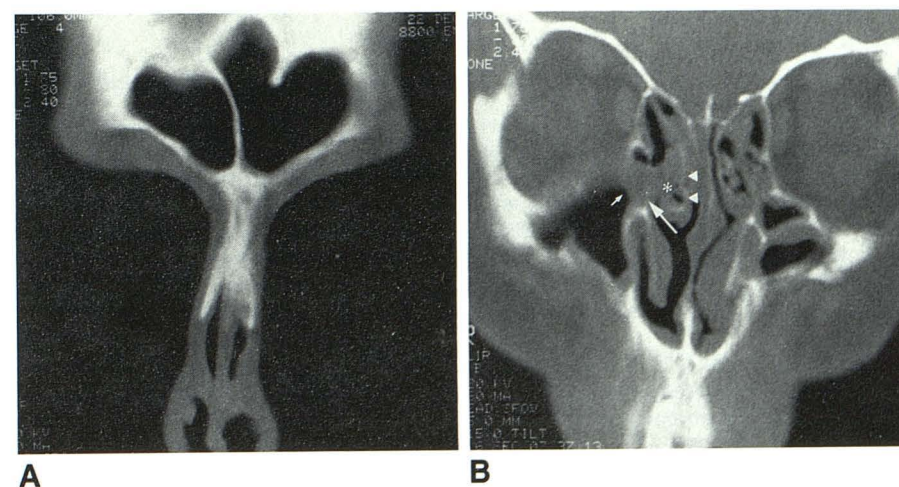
A and B, Normal frontal sinuses (A) and coronal CT scan at level of maxillary sinus ostia (B). Bilateral osteomeatal complex disease and bilateral maxillary sinusitis. Small arrow = occluded maxillary sinus ostium and infundibulum; long arrow = uncinete process; asterisk = expected location of middle meatus; arrowheads = middle turbinate.
